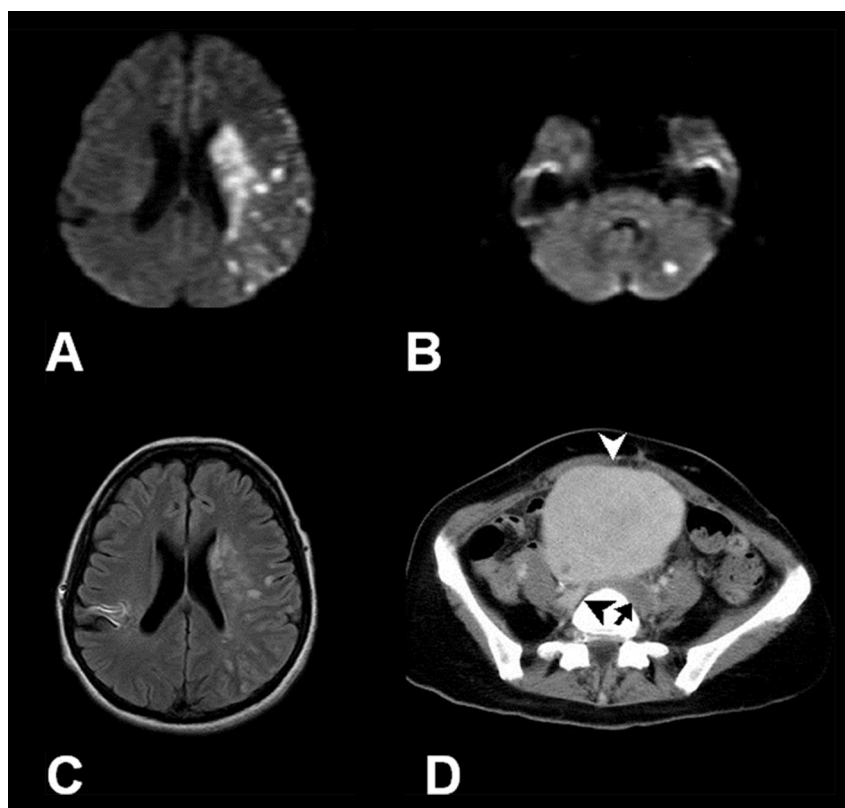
(A) Diffusion weighted brain MRI image showing a fresh cerebral infarction in the left MCA area, (B) a fresh cerebral infarction in the left cerebellar hemisphere. (C) A FLAIR image of the brain MRI shows an old infarction in the right MCA area. (D) Enhanced CT reveals severe compression at bifurcation of the inferior vena cava due to a massive uterine myoma 10 cm in diameter (white arrow head) and DVT in the left common iliac vein (black arrow). The right common iliac vein (black arrow head) shows normal enhancement.
